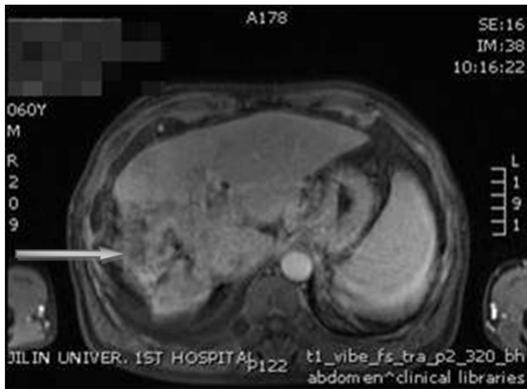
Hepatic contrast-enhanced computed tomography image shows liver cirrhosis and HCC lesions.
